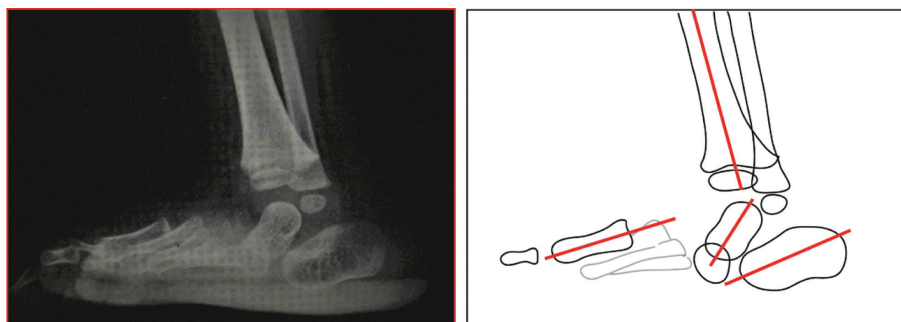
Lateral view radiograph of the foot of a child with severe flatfoot. The talus is markedly plantarflexed, the talonavicular joint is dislocated, and the hindfoot is in valgus.
